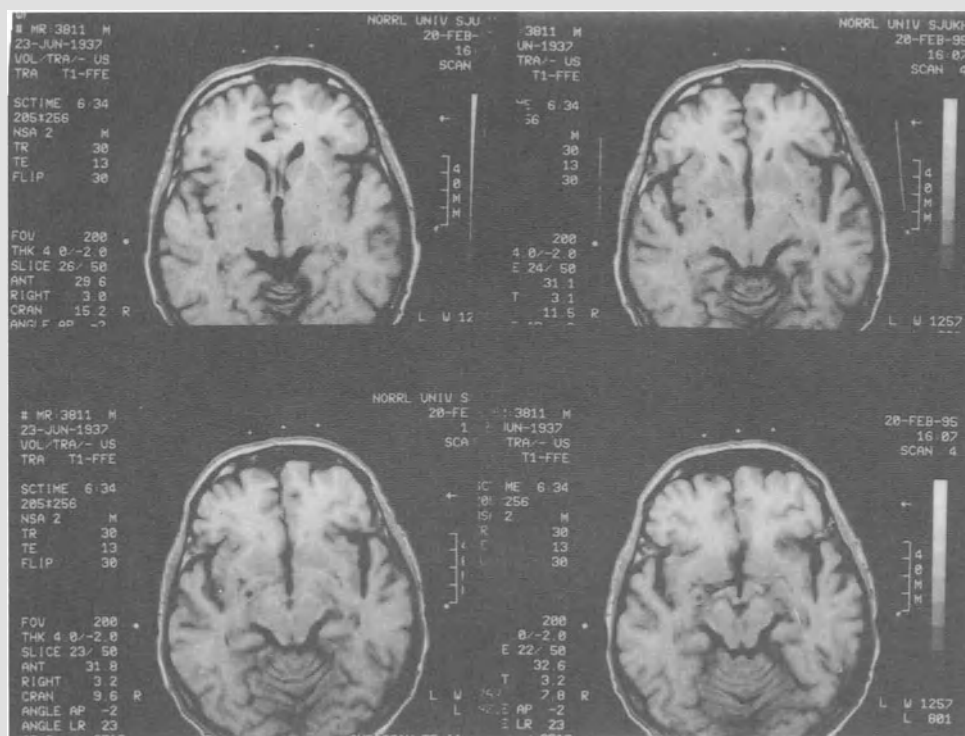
Stereotactic 2 mm-thick axial MRI scans showing a 6 months-old RF lesion in the right pallidum. The lesion lies 22 mm lateral to the midline of the third ventricle at the most posteroventral edge of the right pallidum and encroaches on the dorsal amygdala, just lateral to the optic tract. (A putaminal lacune is visualized anterior and lateral to the pallidal lesion)
